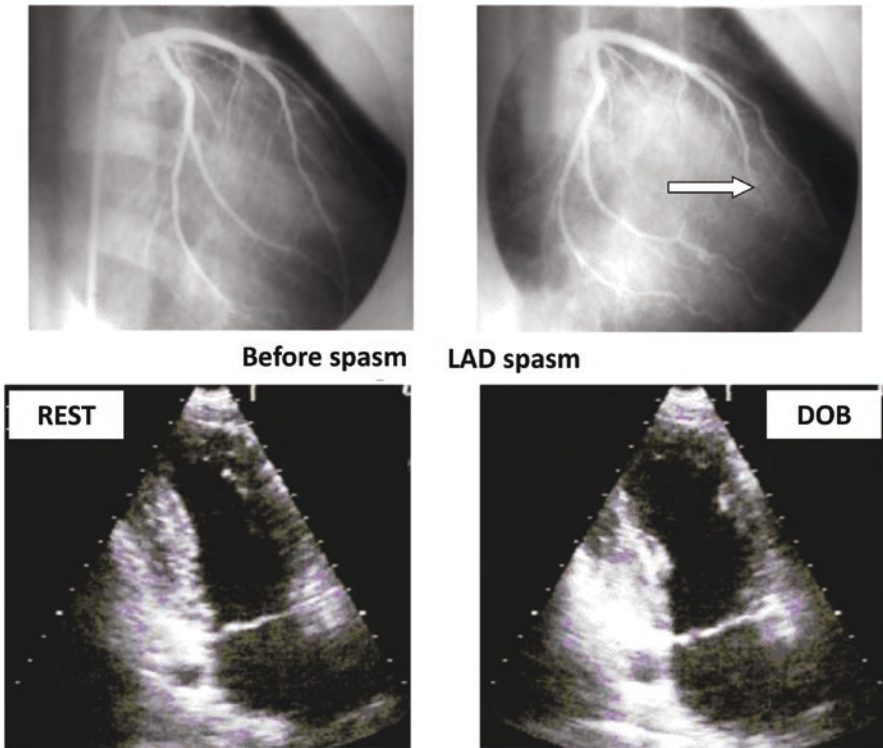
Normal coronary angiogram (left upper panel) and spontaneous spasm of the left anterior descending coronary artery (indicated by arrow) during coronary angiography (right upper panel). In the lower panels, end-systolic frames from the apical two-chamber view showing normal thickening at rest (left lower panel) and akinesia of the anterior wall and inferior-apical segments during peak dobutamine dose. (Modified from Varga et al. [50])
